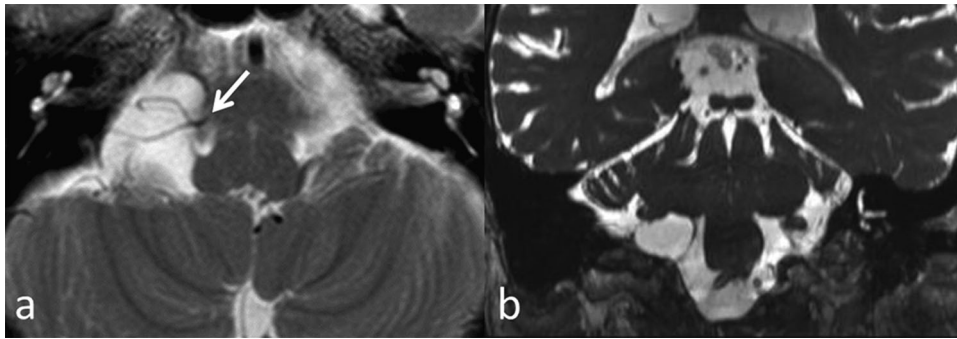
The axial T2-weighted (a) and coronal (b) images show high-intensity area on the right cerebellopontine angle. The branches of anterior inferior cerebellar artery are displaced by the cyst and compress the root exit zone of the facial nerve (solid arrow).
